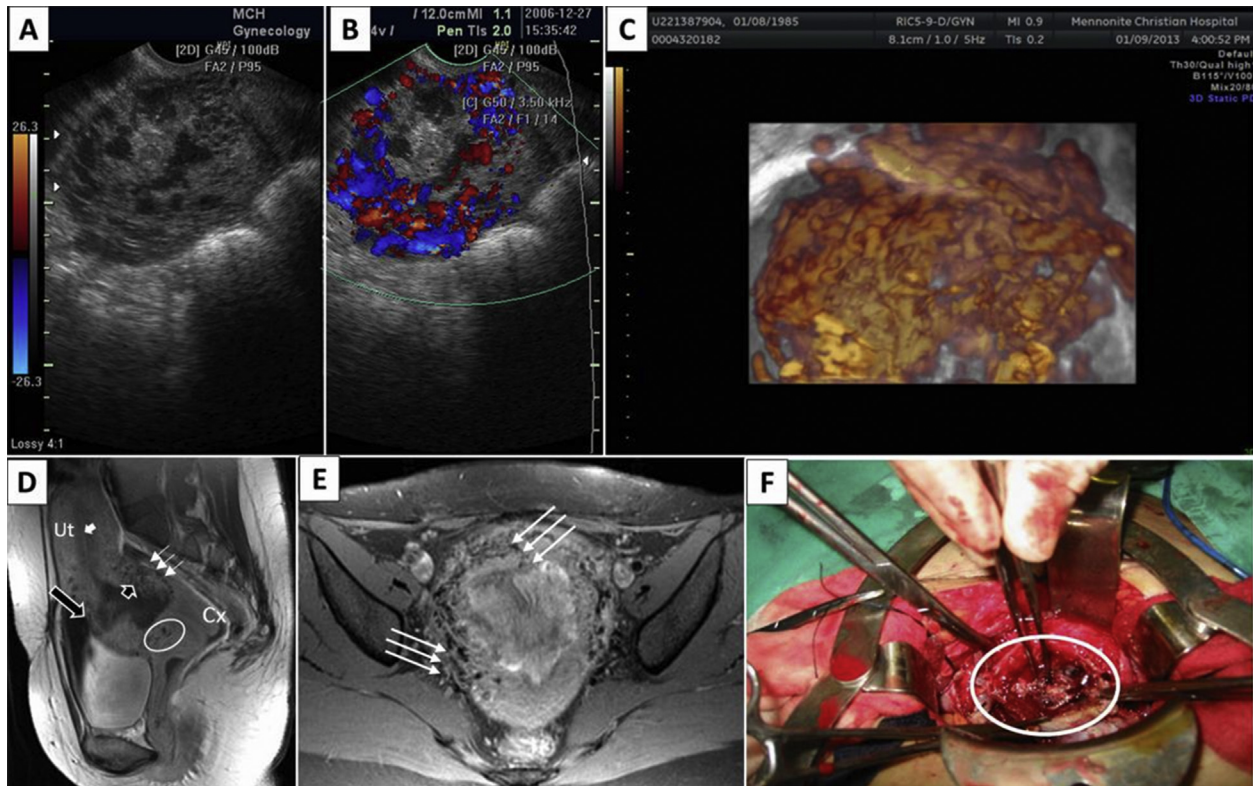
(A) Grayscale image shows localized heterogeneous mass in the lower uterine segment associated with irregular lacunae and absent hyperechogenic edges/interfaces. (B) Color Doppler image shows diffuse lacunar flow with high peak systolic velocity (PSV, 39.27 cm/s) and low resistance index (RI, 0.37) on spectral Doppler analysis. (C) Three-dimensional power Doppler demonstrates extensive and chaotic hypervascularity in the lower segment of uterus. (D) Postcontrast T1-weighted sequence shows multiple vascular serpentine structures characterized by areas of flow void in the posterior and lower segment of the myometrium (white arrows). Mild uterine bulging is noted at lower segment. Normal hypointense endometrium (white arrow head) is interrupted at lower segment (short black arrow). Focal area of signal change and flow voids in the anterior lower segment and endocervix is compatible with invasive placental mass (white oval circle). Triangular area of decreased signal intensity in the lower anterior myometrium (long black arrow) represents site of prior cesarean sections. (E) Axial T1-weighted sequence shows multiple vascular serpentine structures characterized by flow void diffusely encircles the whole lower segment of myometrium and parametrium (white arrows). (F) Mass with protruding villi invades the anterior myometrium of the lower uterine segment and endocervix (white oval circle).
